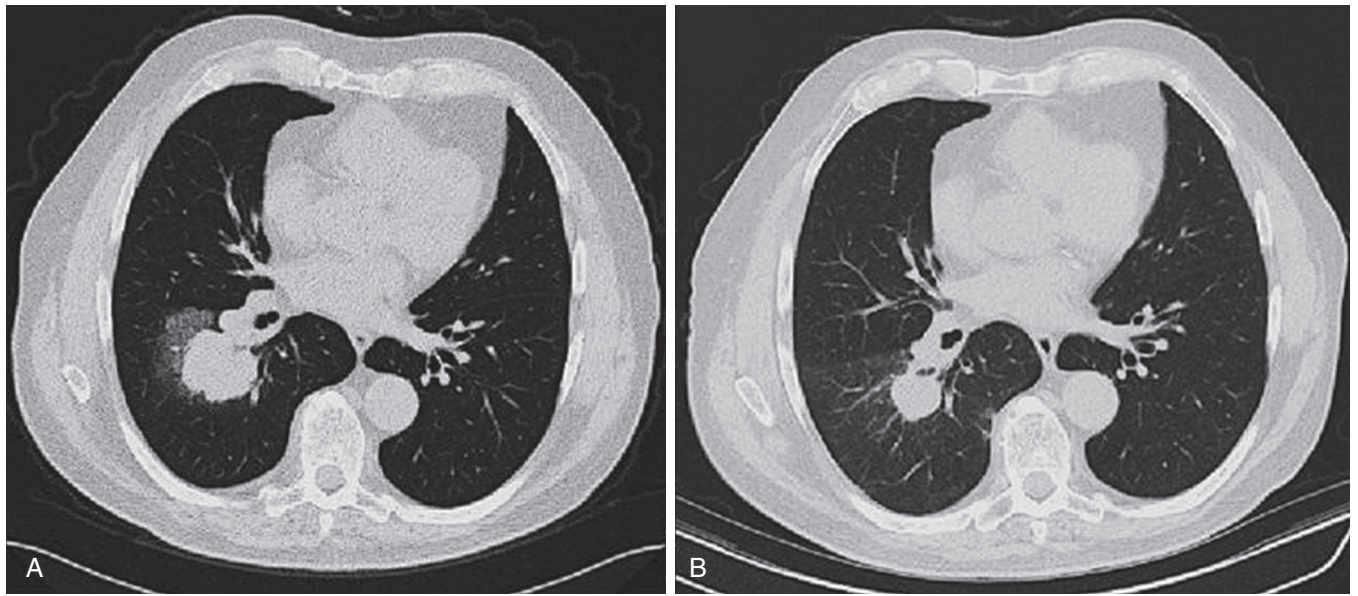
■ Pre- (A) and post-induction (B) chemoradiotherapy chest computed tomographic images in a patient with stage IIIA non-small cell lung cancer (NSCLC). Note the reduction in size of the primary lesion and peritumoral ground-glass opacity after therapy.
